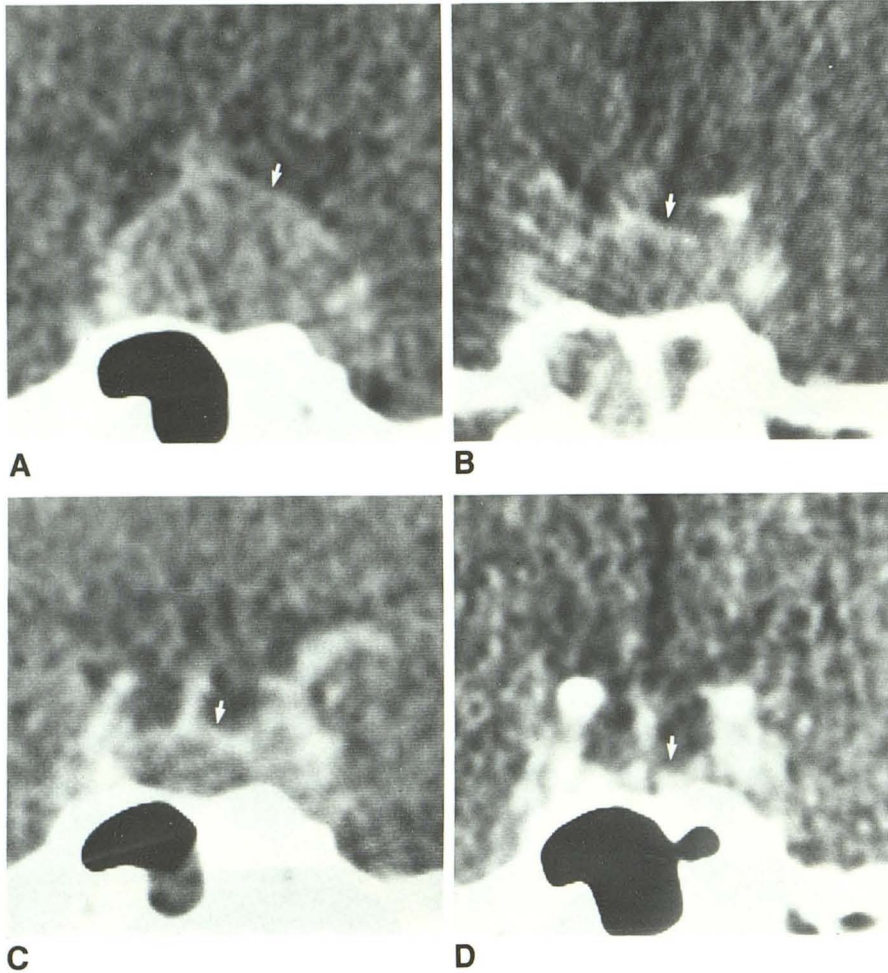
Case 10. Coronal CT appearance of pituitary adenoma after transsphenoidal hypophysectomy. The scale in each image is adjusted to be the same. Upper margin of pituitary mass is indicated by arrow.
